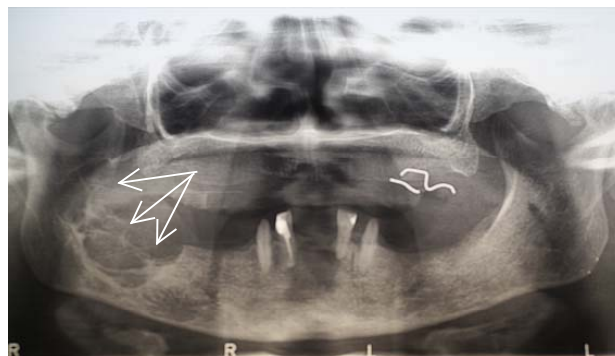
Orthopantomographic radiography at the time of examination: a large elliptical multilocular radiolucency, located on the right side of the mandible, with radiographic evidence of cortical perforation (arrows).
